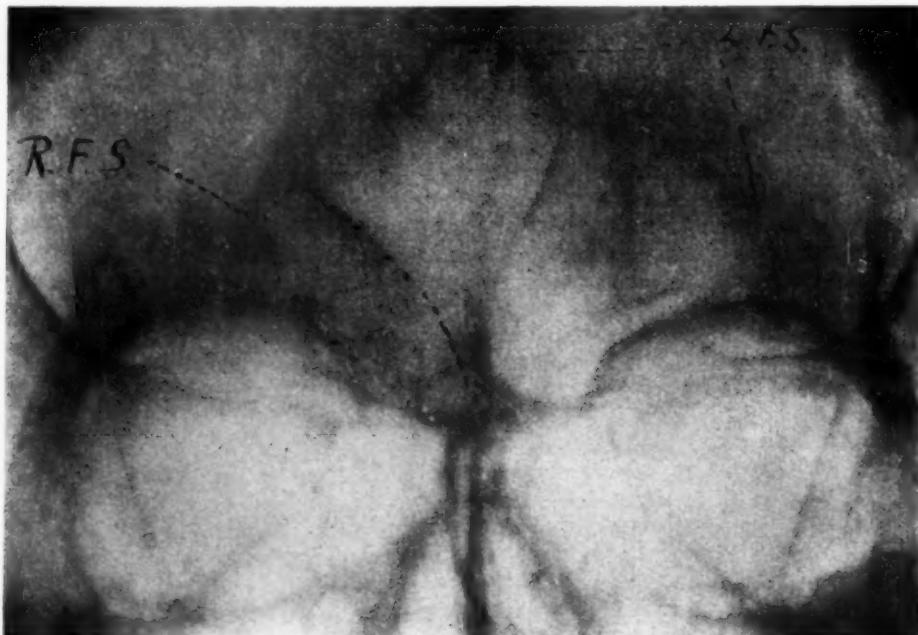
X-ray of sinuses February 26, 1924 R. F. S. Small cloudy sinus. L. F. S. Very large clear sinus.
